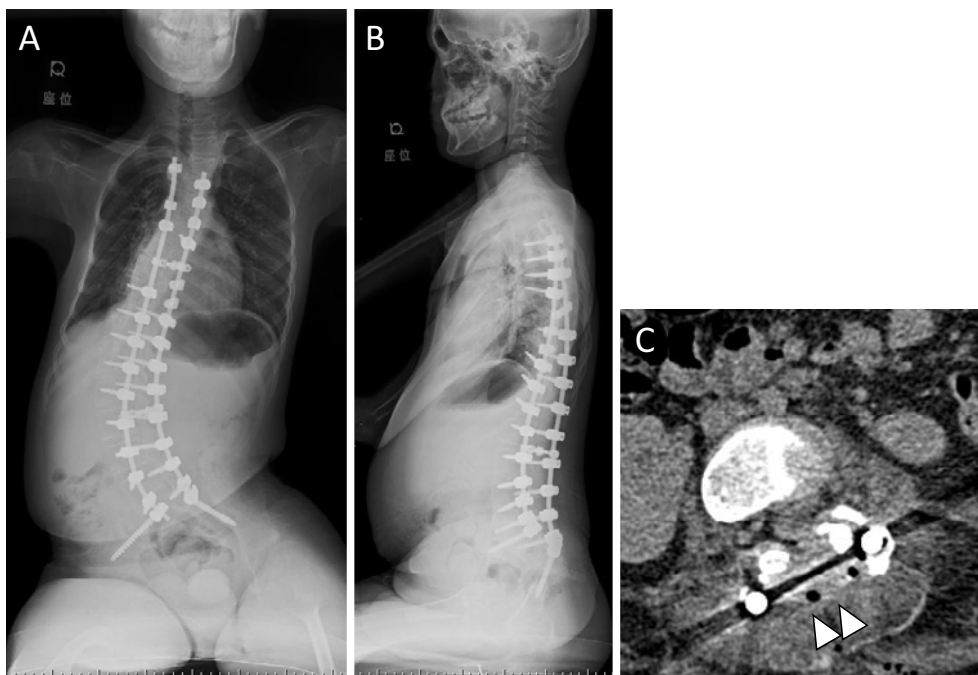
Postoperative X-ray image and CT image of representative case with scoliosis secondary to SMA. Frontal (A) and lateral view (B) X-ray images while the patient was sitting and axial CT image at the laminectomy site. Postoperative Cobb angle was 52° while sitting, and the Cobb angle correction was 55%. (C) Arrowheads indicate the laminectomy site at the L3 level.
